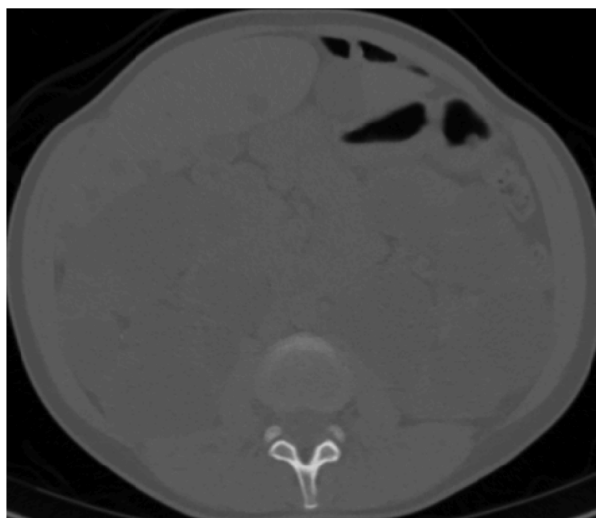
Original computed tomography image.
